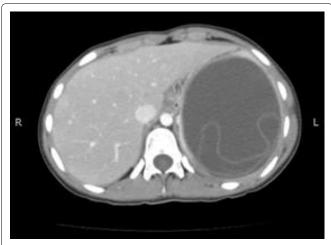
CT scan (sagittal view) of hydatid cyst 'reported' to be within spleen.
